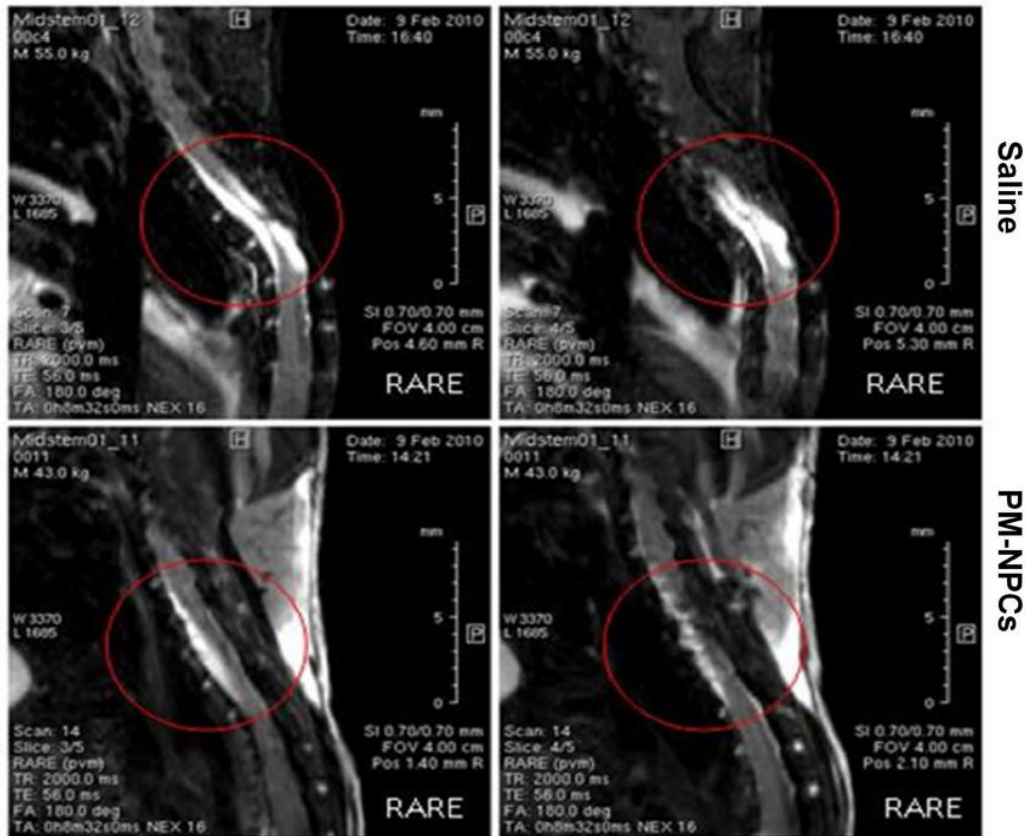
In Vivo MRI 10 Months After Spinal Cord Injury.
